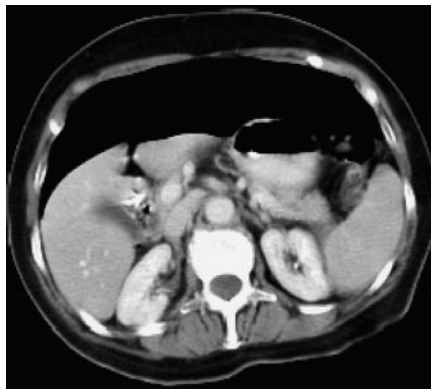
Abdominal computed tomogram taken soon after closure of the perforation, showing free air in the peritoneum and the clips in place.
